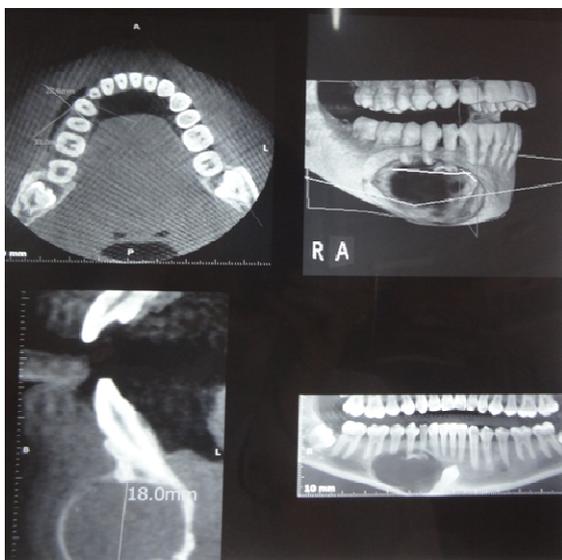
Radiographic view of lesion showing large unilocular radiolucency associated with expansion of cortical plates
